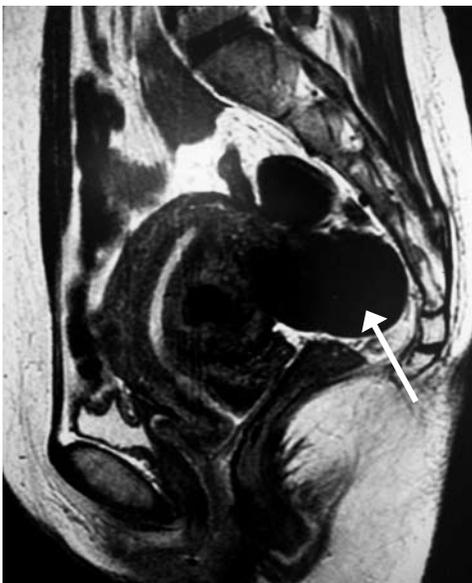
Plane T2-weighted MR imaging. The MRI showed uterine myoma (white arrow).
